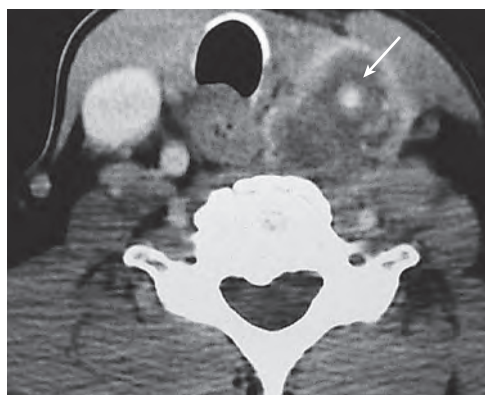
A computed tomography scan of the patient shown in Fig. 12.9.
